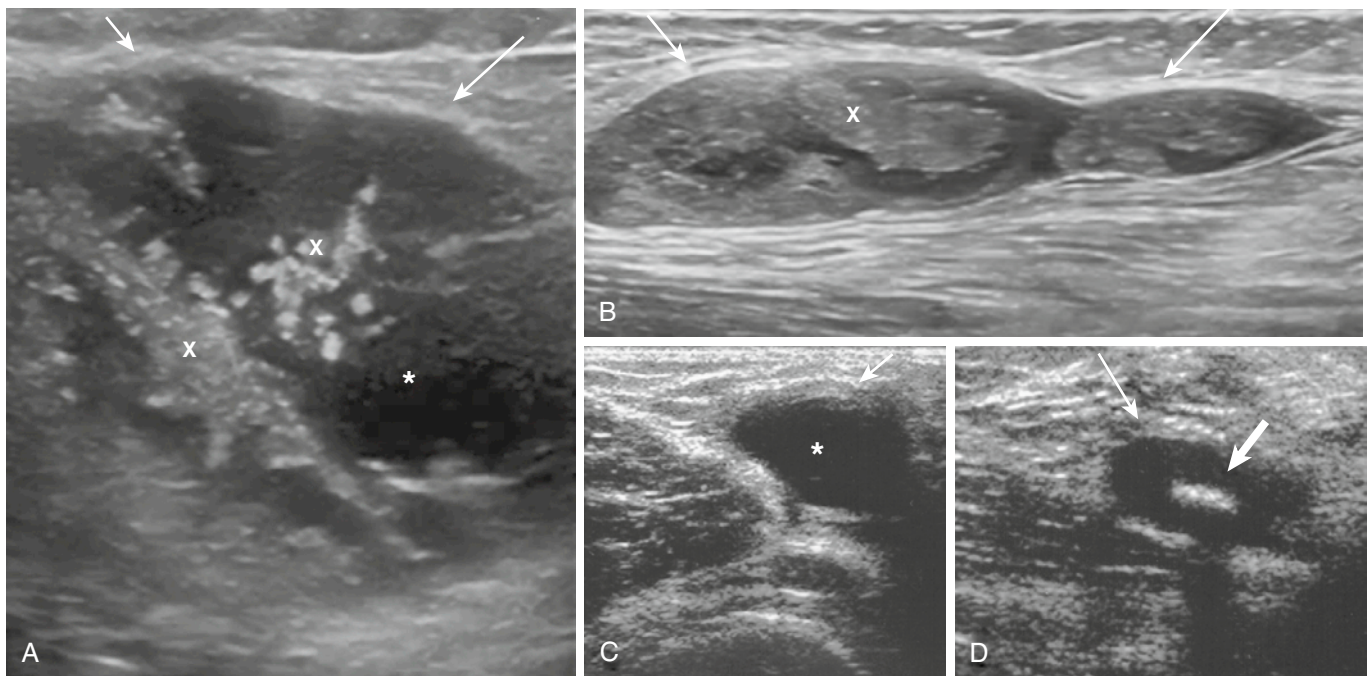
Ultrasound is used to evaluate the calf in patients with knee osteoarthritis and calf swelling. A-D, The 12-MHz images show Baker's cysts having mixed contents of local effusion (*stars*), synovial thickening and proliferation (*X*), and internal calcifications (*thick arrow*), causing distention of the bursal wall (*thin arrow* in D).
